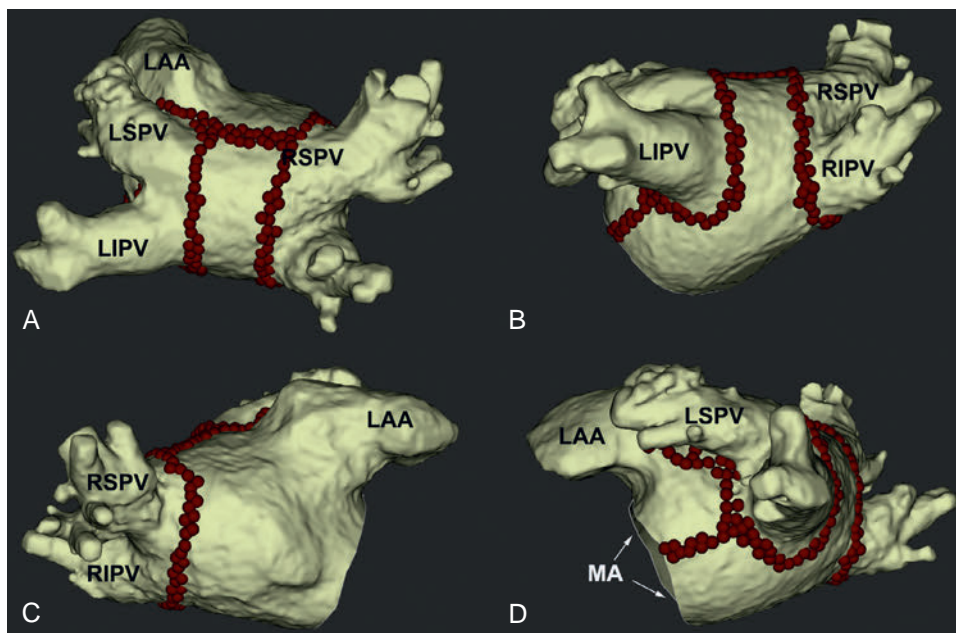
Circumferential Left Atrial Ablation. Segmented three-dimensional computed tomography scan of the left atrium (LA) and pulmonary veins (PVs) shown in posteroanterior (A), modified posteroanterior (B), right anterior oblique (C), and left lateral (D) views. Contiguous radiofrequency lesions (red dots) are deployed in the LA, creating circumferential lines around ipsilateral PVs. An ablation line is also created across the LA roof to connect the two circumferential ablation lines and another ablation line across the lateral mitral isthmus between the inferior portion of the left-sided encircling lesion and the lateral mitral annulus. LAA, LA appendage; LIPV, left inferior PV; LSPV, left superior PV; MA, mitral annulus; RIPV, right inferior PV; RSPV, right superior PV.
